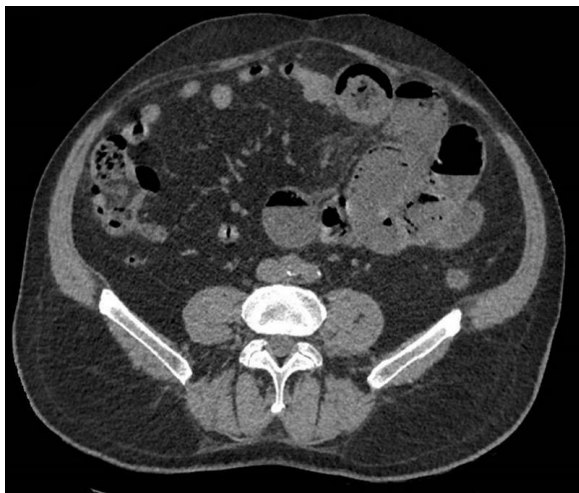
Abdominal computed tomography (CT) showing dilated jejunal loops up to 45 mm and free fluid, compatible with occlusion caused by a flange or internal hernia.
